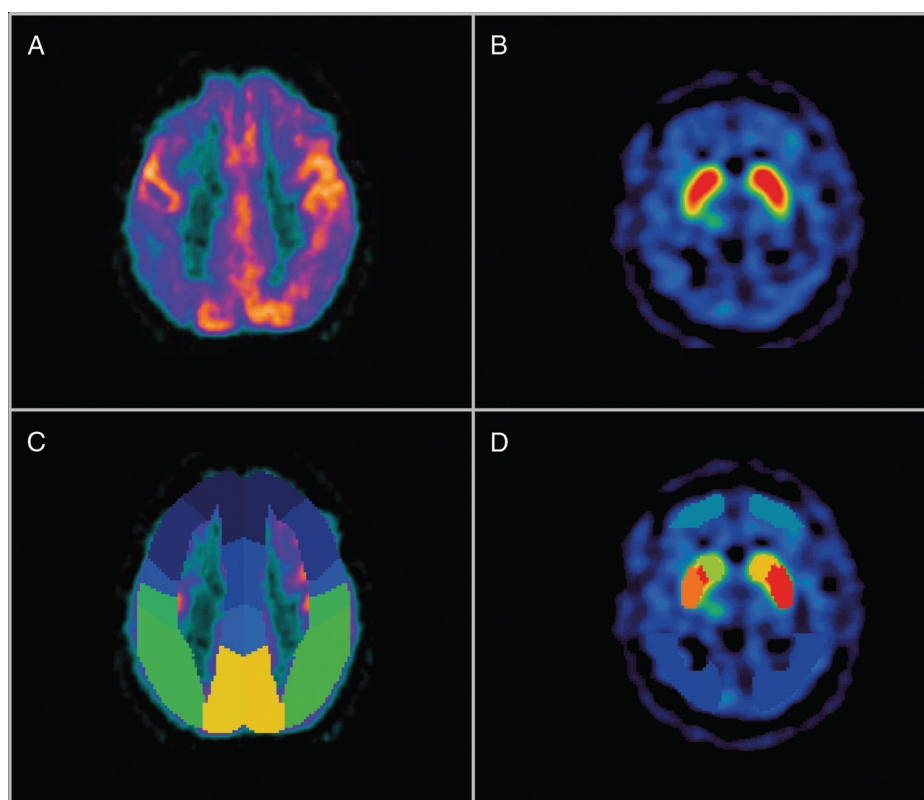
A and B, Normalized images of FDG-PET (A) and DaTSCAN SPECT (B) in a patient with a clinical diagnosis of AD and typical imaging findings: the DAT binding is within the normal range, and the glucose metabolism is reduced in the temporoparietal regions, bilaterally. C and D, Corresponding VOI maps in the BRASS software, overlaid on the normalized images.
